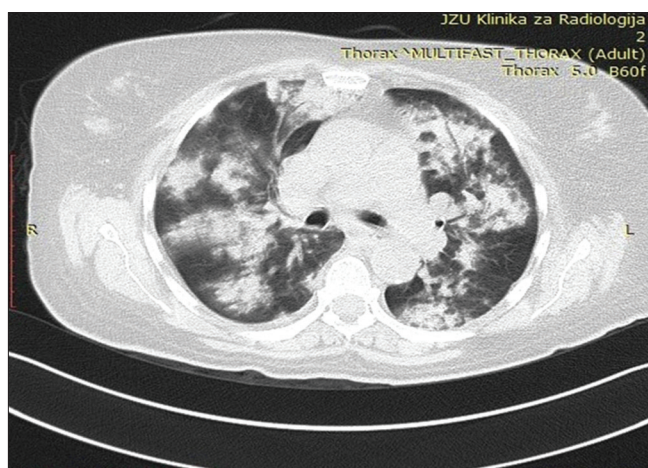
Findings of computed tomography lung scan at admission in the department of nephrology were suggestive for diffuse alveolar hemorrhage
